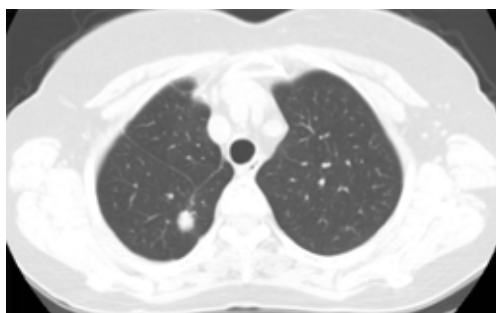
Follow-up computed tomography (CT) of the chest showing a round mass in the superior segment of the right lower lobe.
